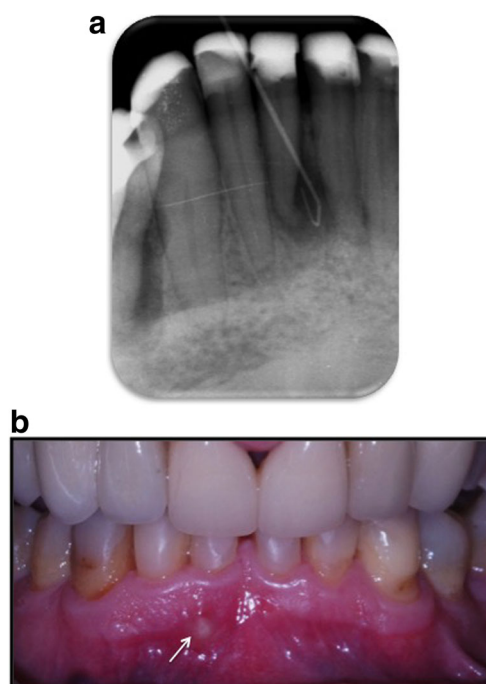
a, b Case #1 initial radiograph and clinical picture of the tooth #41 together with gutta percha indicating the presence of the fistula tract and AP
